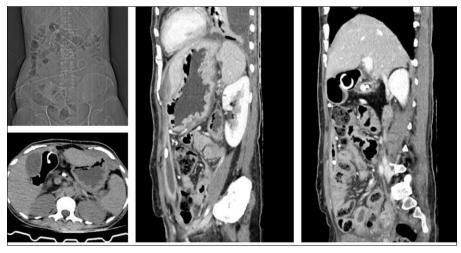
Repeat CT Abdomen suggestive of thin rim of collection at anterior infraumbilical location, along with significant reduction in pelvic, left hypochondriac, lesser sac collections
